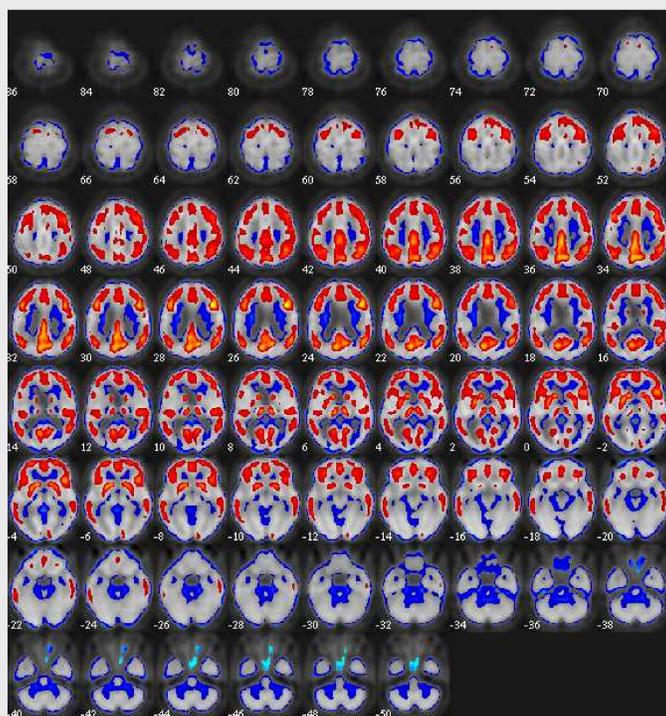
ICA on patient FDG-PET data set. Independent component involving regions of the default mode network.
